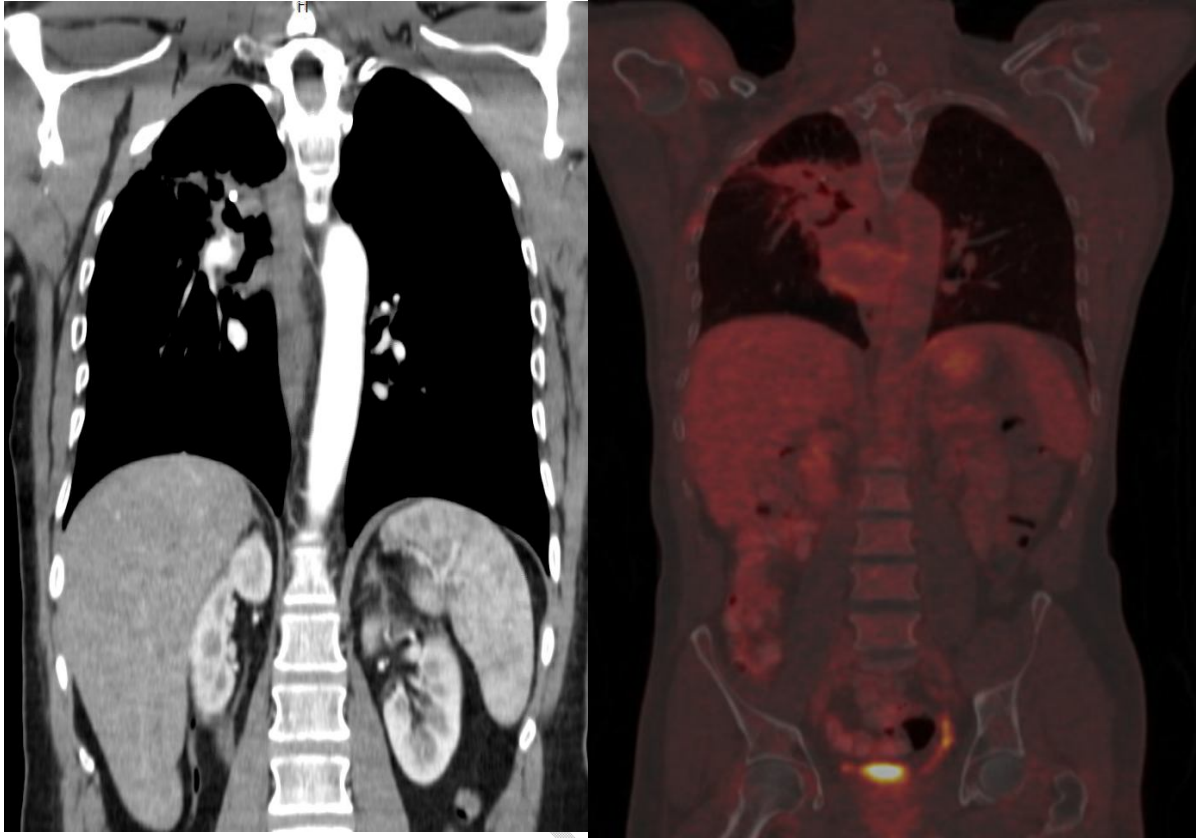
PET and CT scan conducted in 2018
